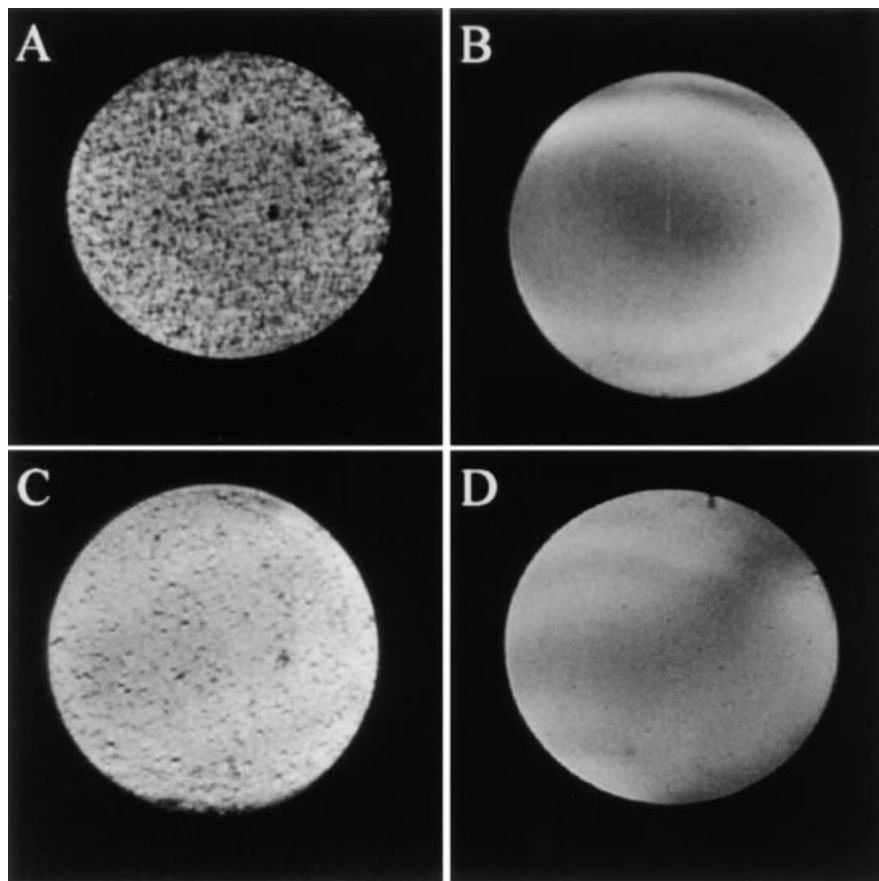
Gradient-echo magnetic resonance (MR) images showing ultrasmall superparamagnetic iron oxide (USPIO)-labeled (A and C) and unlabeled (B and D) macrophage samples in vitro. Cell concentrations were as follows: (A and B), 2.0×10^6 cells/mL and (C and D), 0.5×10^6 cells/mL. Bulk samples for these high-resolution MRI studies were prepared in 1 mL plastic syringes by suspending labeled or unlabeled macrophages in 5% gelatin. The dark spots in A and C appear to represent single USPIO-labeled macrophages. The slow varying shadow seen in (B and D) are believed to be due to bulk field inhomogeneity brought about by imperfect shimming of the magnet.
